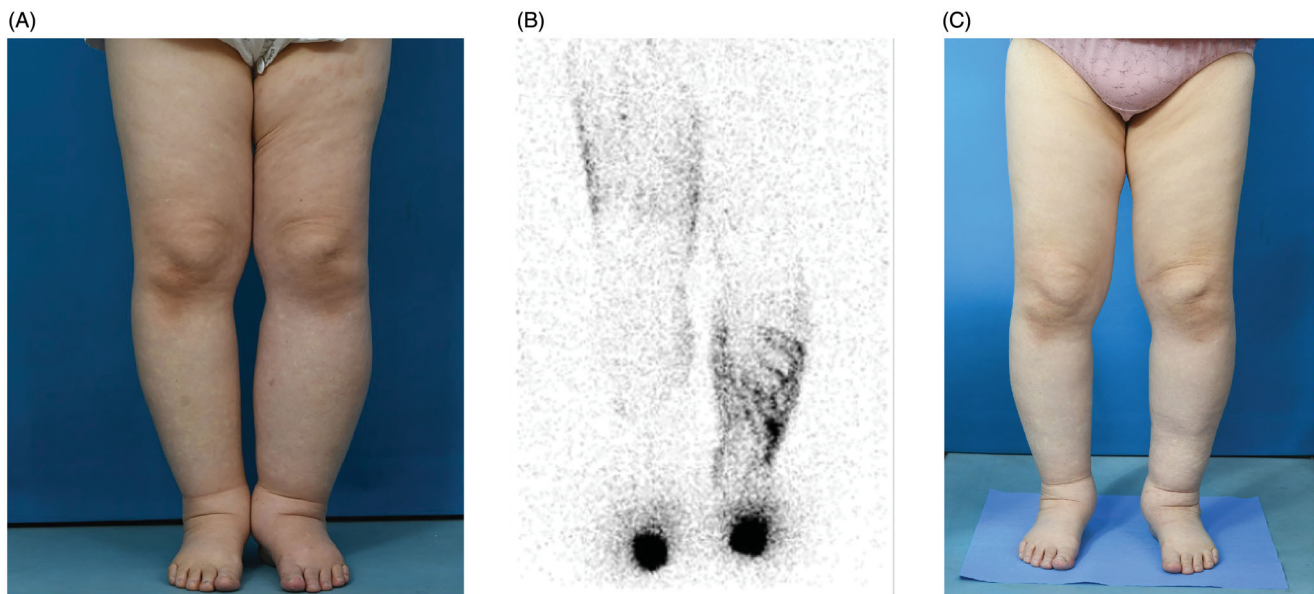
Pre- and postoperative clinical images of Patient no. 6. (A) A 69-year-old woman had suffered bilateral lower extremity lymphedema for 6 years following a hysterectomy. The LEL index at her left leg was 270.6 preoperatively. (B) Preoperative lymphoscintigraphy showed a significant amount of dermal back flow in both lower extremities, in which the left side showed a worse condition. (C) Simultaneous supraclavicular lymph node transfer and three lymphaticovenular anastomoses at the dorsum of foot, ankle and the superior edge of the knee were performed. At 14 months, her left LEL index was reduced to 248.6 postoperatively.
